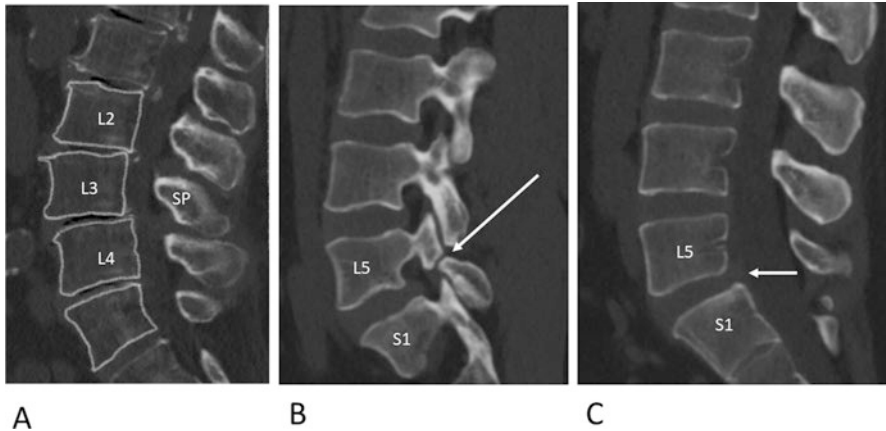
CT scan of the lumbar spine showing degenerative spondylolisthesis (a), spondylolysis (b), and isthmus spondylolisthesis (c). (a) a midsagittal image showing the anterior slippage of L3 in relation to adjunct vertebrae. Note that the spinous process (SP) of L3 is also positioned more ventral. (b) a parasagittal image showing a fracture of the left isthmus of L5 (white arrow). (c) a midsagittal image showing the ventral slippage of the L5 vertebral body due to isthmus spondylolysis. Note that the spinous process did not move more ventral
